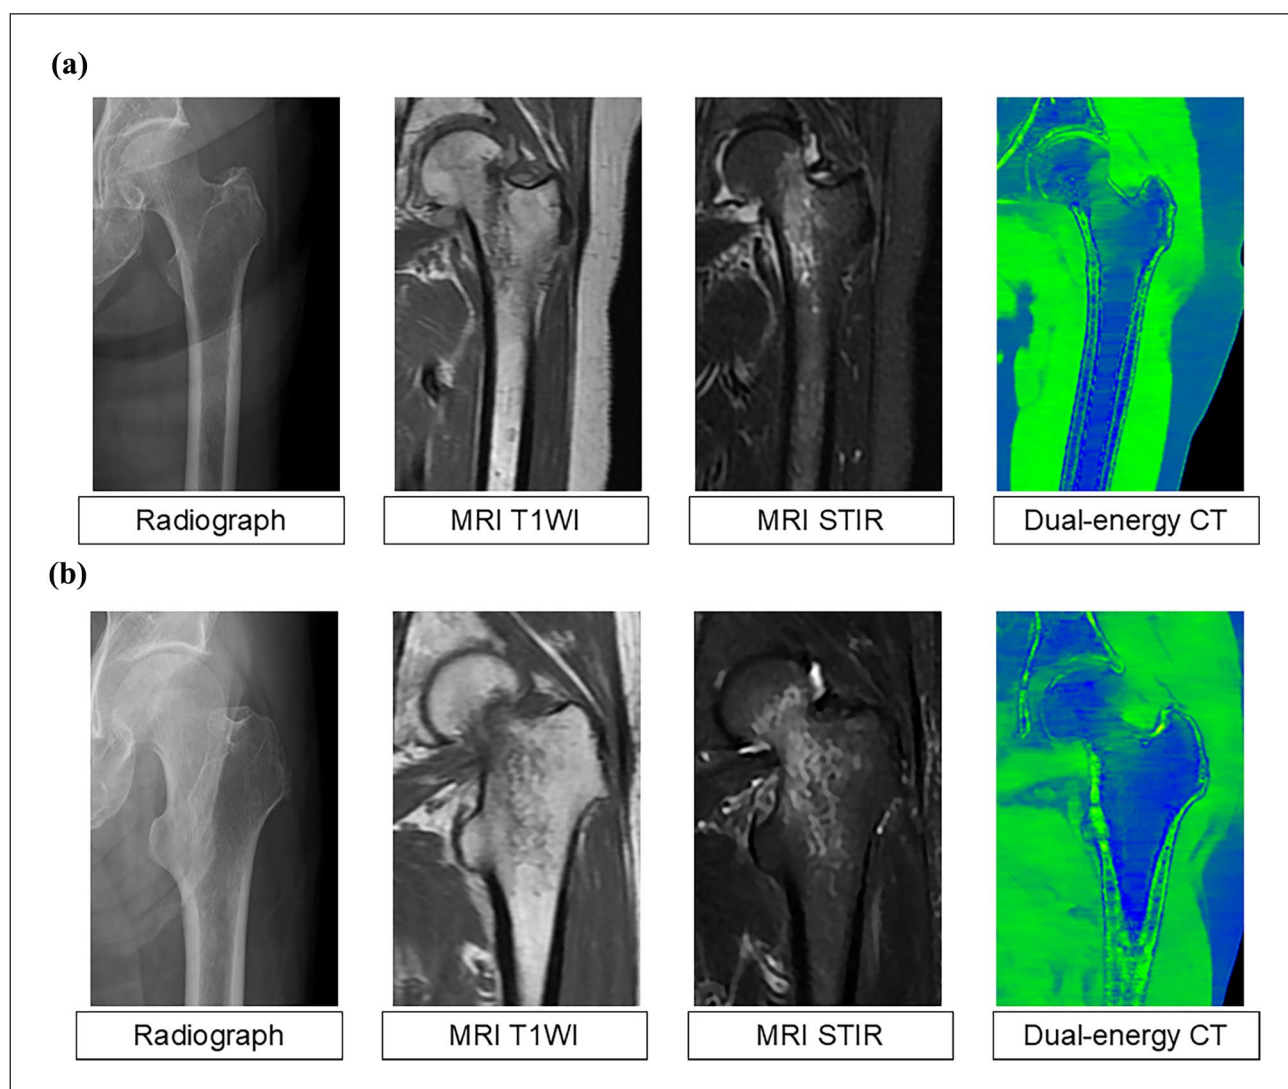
Representative images of a femoral trochanteric fracture (a) and a femoral neck fracture (b). In the dual-energy computed tomography images, bone marrow edema is highlighted in green across the intertrochanteric line.
